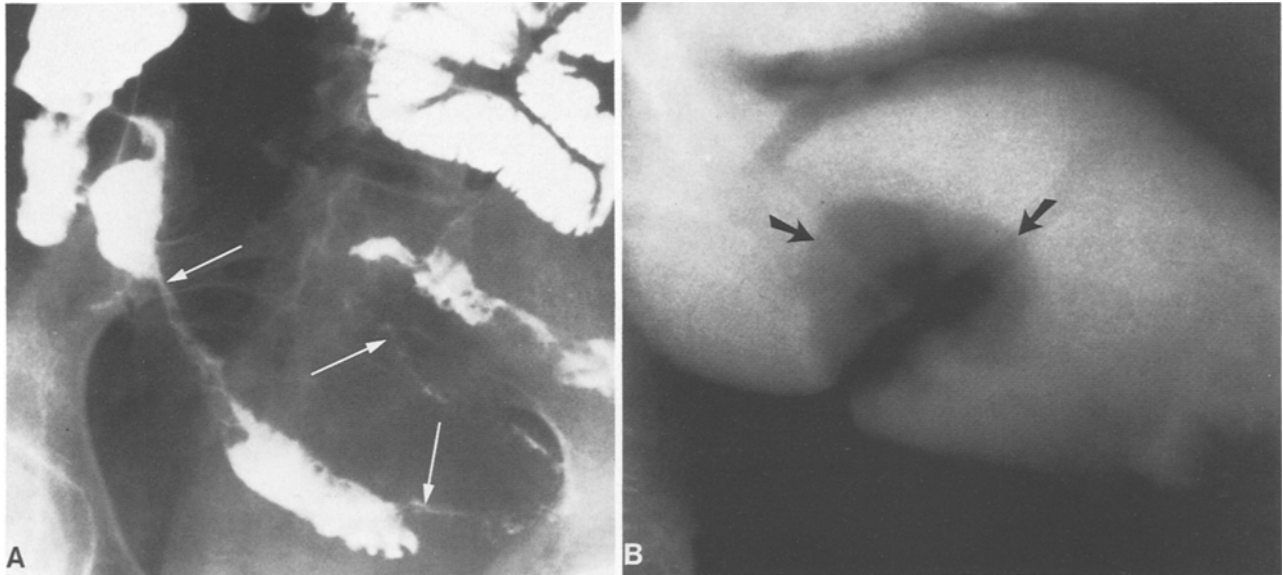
Patient 3, a 53-year-old woman with a 15-year history of regional enteritis. A A small bowel examination reveals eccentric narrowing and a “cobblestone” appearance in the distal ileum (*arrows*). B Three years later the patient presented with a carcinoma of the rectum. The radiographic appearance on a barium enema is typical for a lobular polypoid cancer (*arrows*).
